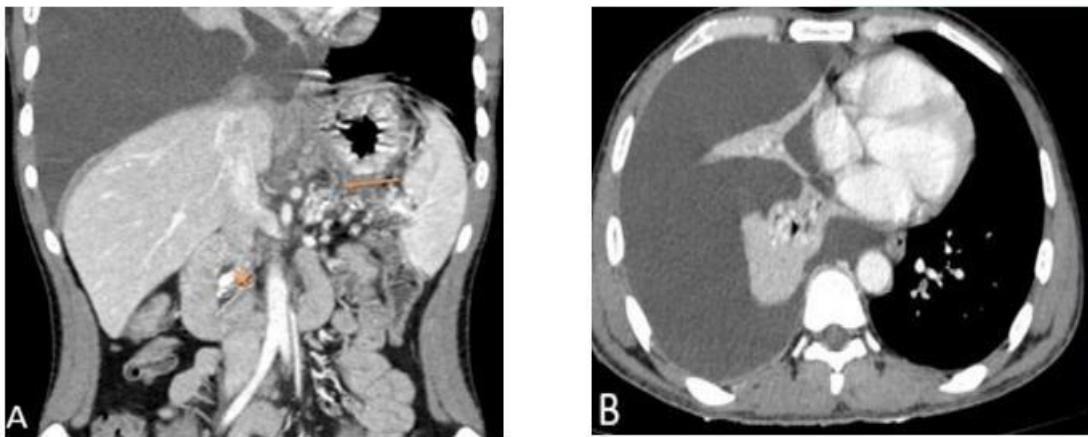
Contrast-enhanced CT images (A – coronal, B – axial) showing features of chronic calcific pancreatitis with an enhancing fistulous tract arising from the pancreatic tail and extending superiorly into the right pleural cavity, resulting in massive right-sided pleural effusion consistent with pancreatico-pleural fistula.
